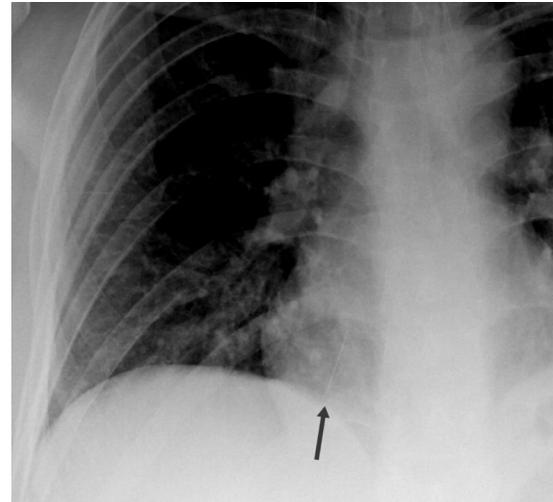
Frontal chest radiograph. Arrow indicates a thin linear density over the right cardiac shadow.
